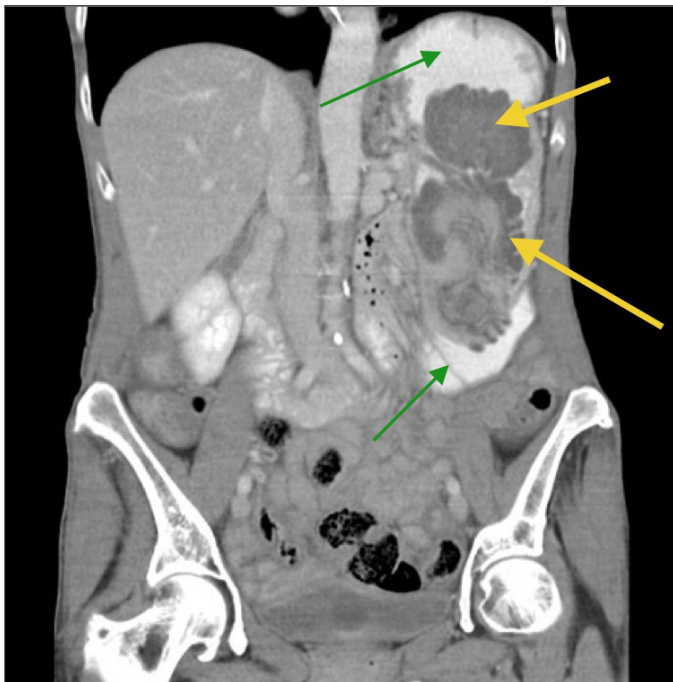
Abdominal/pelvic CT showing a large retrograde jejuno-gastric intussusception with intragastric strangulation of jejunal loops via a gastrojejunostomy (yellow arrows). The stomach is distended with oral contrast (green arrows).
